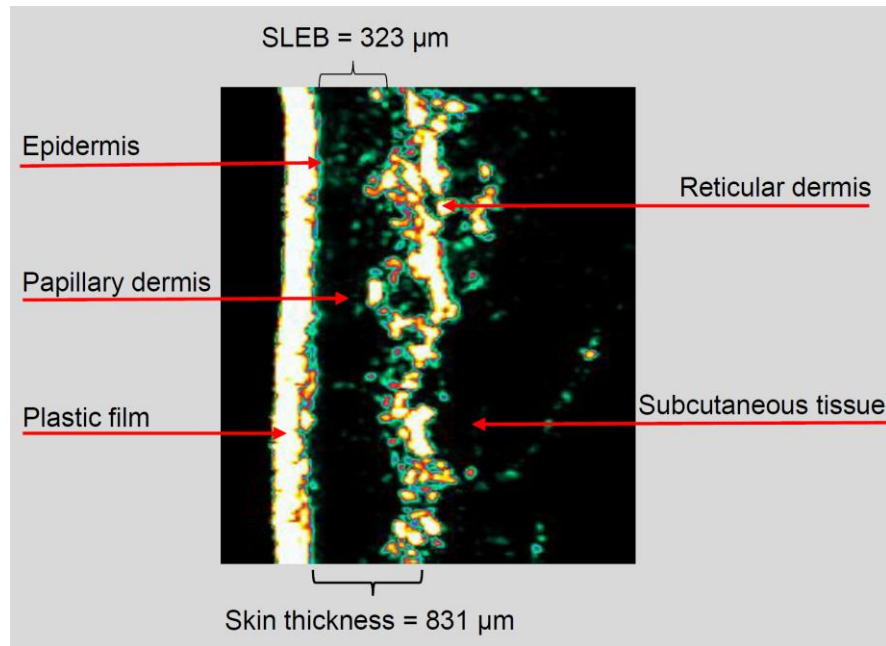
Ultrasound image of the dorsal forearm of an 87 year old female.
